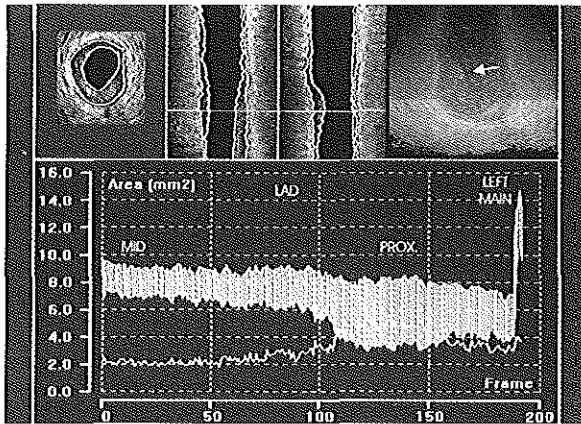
Primary lesion in a proximal left anterior descending coronary artery (LAD), assessed by the three-dimensional intracoronary ultrasound contour detection system of the Thoraxcenter, Rotterdam. An arrowhead indicates the target stenosis in the cylindrical reconstruction. The measurements are shown in the lower panel: The white zone represents the coronary plaque and the upper and lower boundaries of this zone correspond with the values of the coronary lumen and the total vessel areas (mm^2). The absolute values of the plaque area (mm^2) are also shown as a single line. The area stenosis at the site of the mid segment of the LAD was approximately 20%. According to the mechanism described by Glagov, an enlargement of the total vessel area, partly compensating the plaque burden, may be expected at the site of relatively focal plaque formation. In this case, however, a paradoxical reduction of the total vessel area, from the distal reference in the mid LAD (MID) to the target stenosis in the proximal segment (PROX) was observed. (Reproduced with permission^[13].)
